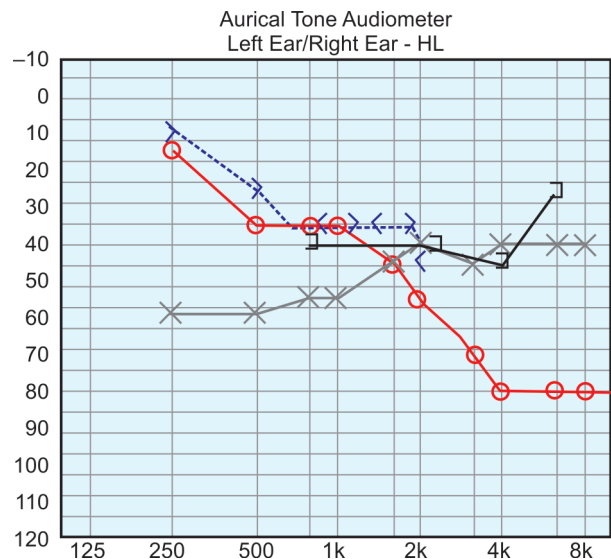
An audiogram of a 4-year-old child referred for a conductive hearing loss. On close examination, the audiogram shows unmasked bone thresholds. The CT scan of this patient is shown in Figure 16.3.
